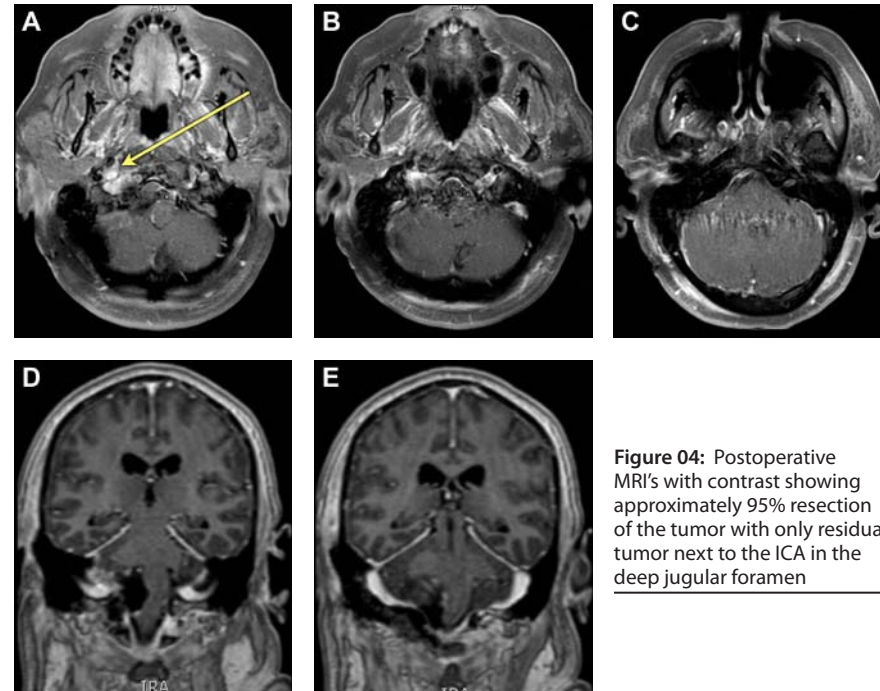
Postoperative MRI's with contrast showing approximately 95% resection of the tumor with only residual tumor next to the ICA in the deep jugular foramen
